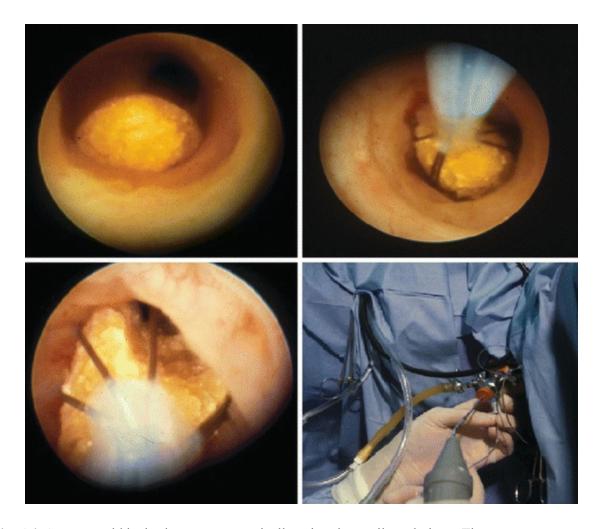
Stones could be broken ureteroscopically using the tactile technique. The stone was visualized, grasped in a basket and pulled to the tip of the ureteroscope. The ultrasound probe was felt against the stone and then as it cleared the stone with fragmentation
